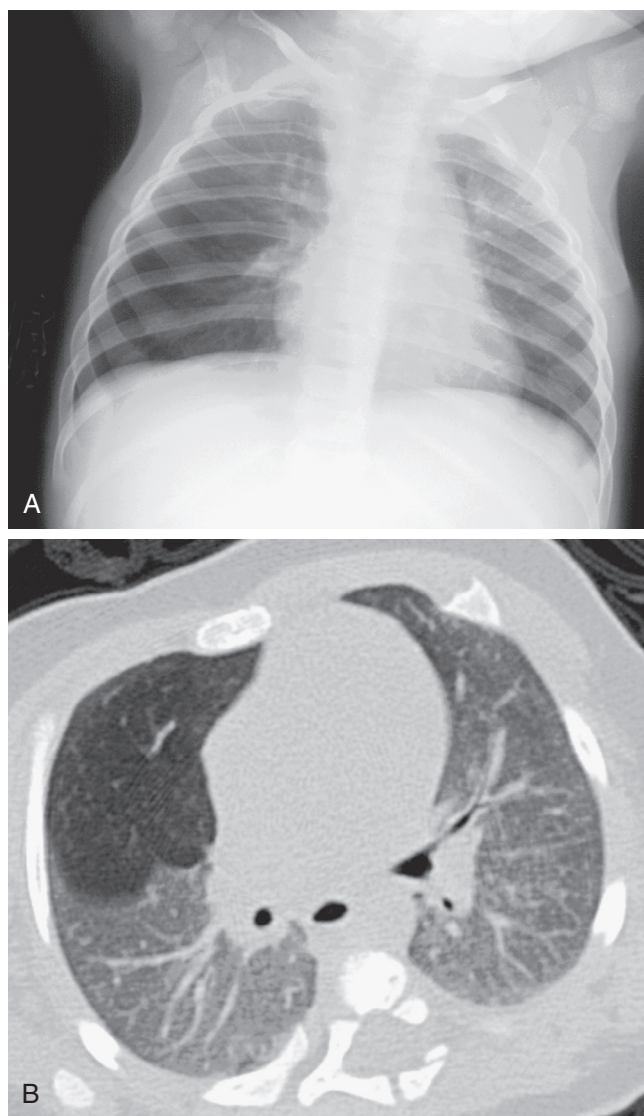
■ Congenital lobar emphysema. A, Chest radiograph of a 1-month-old boy shows hyperlucency in the right lower lung field. B, Computed tomography image of the lungs just below the carinal bifurcation shows right middle lobe emphysema with paucity of blood vessels and decreased attenuation. (Courtesy Simon C. Kao, MD, Iowa City, IA.)
